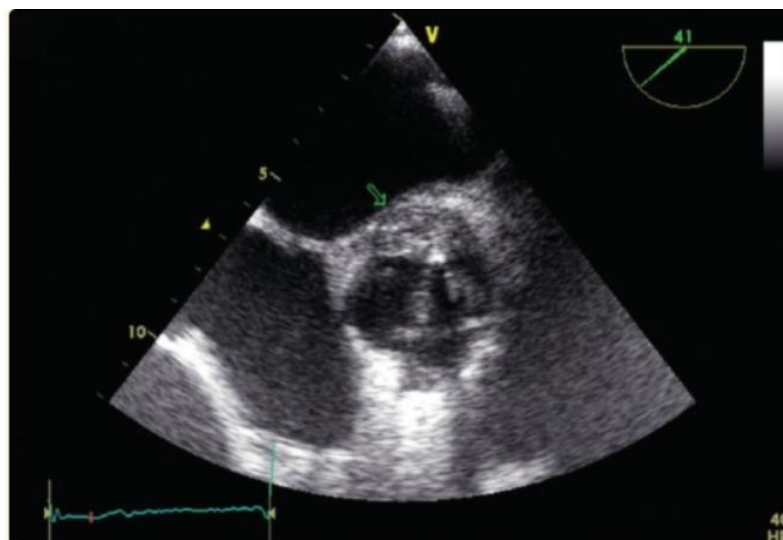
Transesophageal echocardiography, short-axis section: Dense posterior aortic abscess on ultrasound (length 33 mm, thickness 15 mm) [12]
